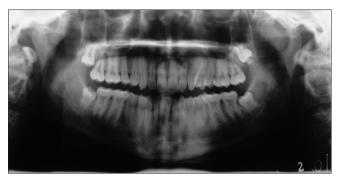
Panoramic radiograph (preoperative)
